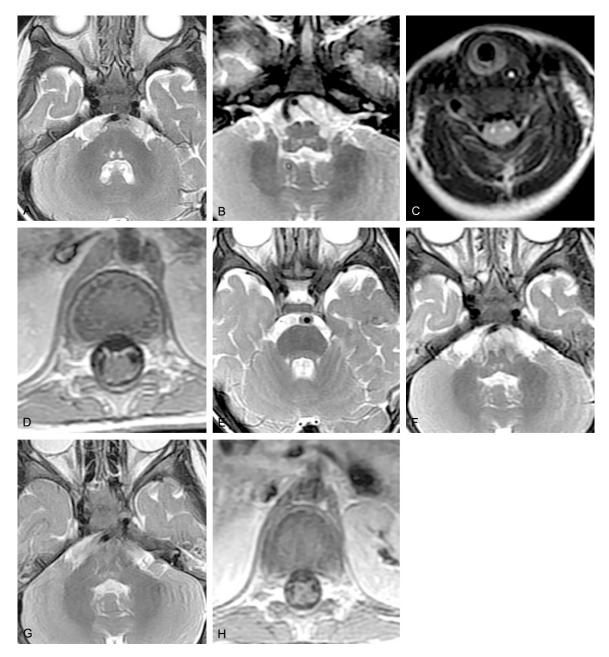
Brain MRI of Case 2. Before treatment: (A) T2-weighted image showing bilateral hyperintense signals in the posterior pons, (B) T2-weighted image showing bilateral hyperintense signals in the posterior medulla oblongata, (C) T2-weighted image showing bilateral hyperintense signals in the anterior roots of the spinal cord, (D) contrast-enhanced image showing enhancement of the bilateral anterior nerve roots. Repeat MRI after 4 weeks: (E) T2-weighted image showing absence of hyperintense signals in the posterior pons, (F) decreased size of the lesion in the medulla oblongata. Repeat MRI after 1 year: (G) partial resolution of the lesion in the medulla oblongata, (H) contrast-enhanced image showing absence of nerve root enhancement.
